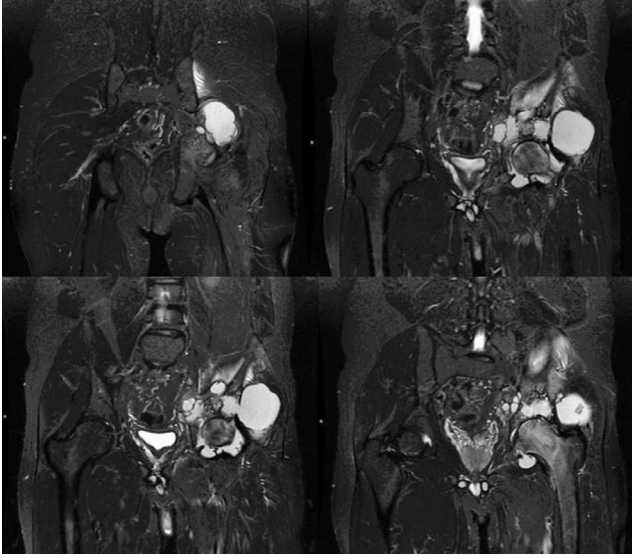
MRI with STIR sequences demonstrates multiple cystic areas at the site of the left acetabular region, the largest of which was 68 x 50 x 76 mm, with some parietal calcifications. There is associated medullary edema of the femoral head and, to a lesser extent, on the left iliac wing adjacent to the sacroiliac synchondrosis, in relation to reactive-phlogistic phenomena. In addition hyperintensity of the iliac muscle and the gluteus medius muscle at their bony insertion.
